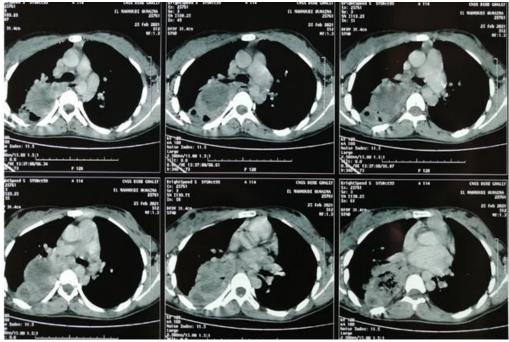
Chest CT scan (2021): excavated hypodense right basithoracic lesion
